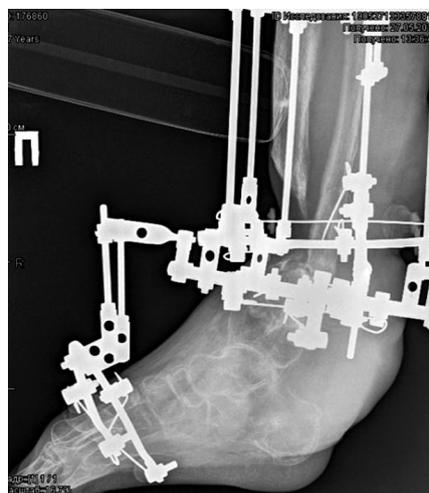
Radiograph of the right foot and lower third of the tibia (lateral view) at the stage of soft-tissue interposition elimination
